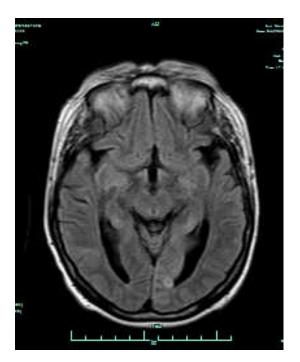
Magnetic Resonance Images: Non-dreaming patient (#8)
